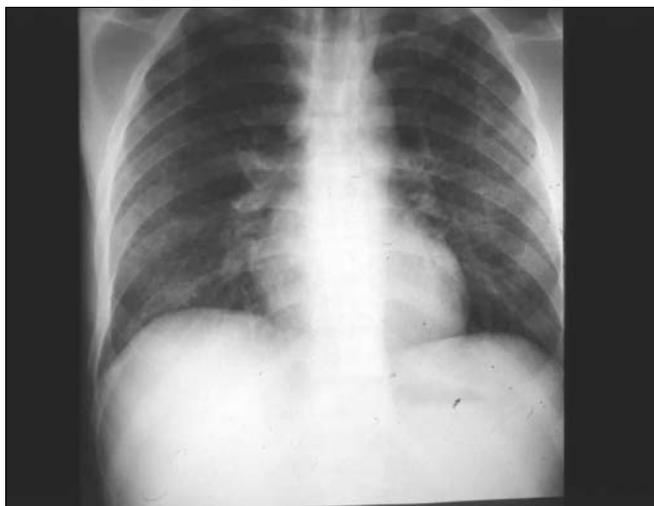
Case 4. Chest radiograph shows miliary pattern.
